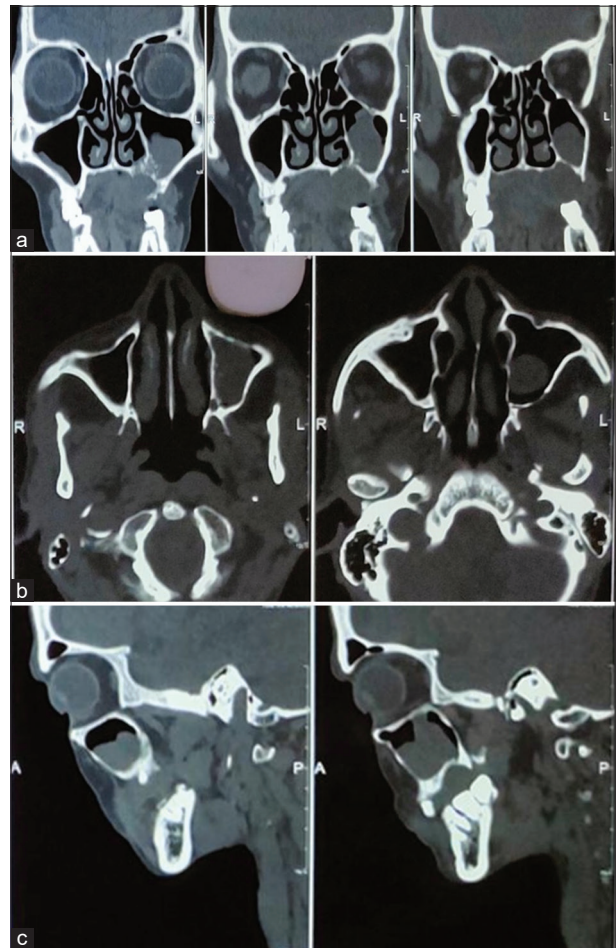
(a) Coronal view-unenhanced computed tomography (CT) image shows an opacified sinus with destructive maxillary sinus tumor. (b) Axial view-unenhanced CT image reconstructed with bone algorithm shows an extensive bony defect of the posterior maxillary sinus wall. (c) Sagittal view shows pterygopalatine fossa invasion accompanied by perineural spread
